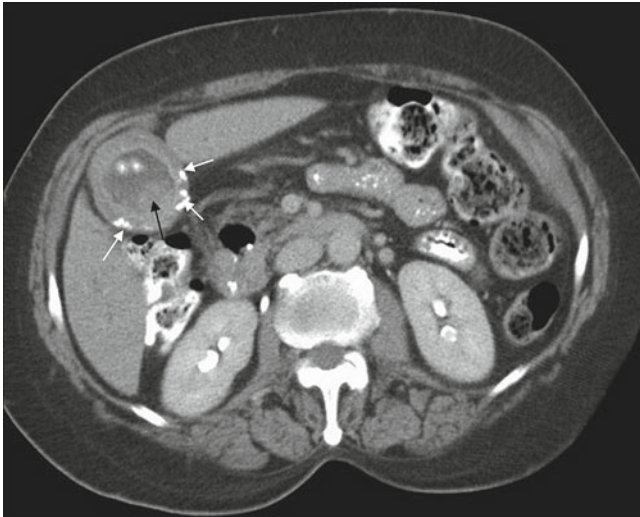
A 77-year-old woman known to have gallstones presents with RUQ abdominal pain for about 6 weeks; she is afebrile. Axial oral and intravenous contrast enhanced CT image through the gallbladder shows thick gallbladder wall (about 6 mm), intermittent gallbladder wall calcification (*white arrows*), two gallstones, and a mass (*black arrows*) protruding into the gallbladder lumen. Diagnosis: Gallstones and gallbladder cancer
